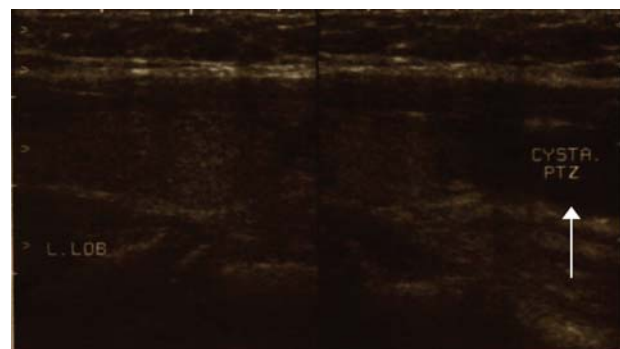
Ultrasound image in the longitudinal section – Directly to the bottom half of the left lobe is a remnant of the cyst.
